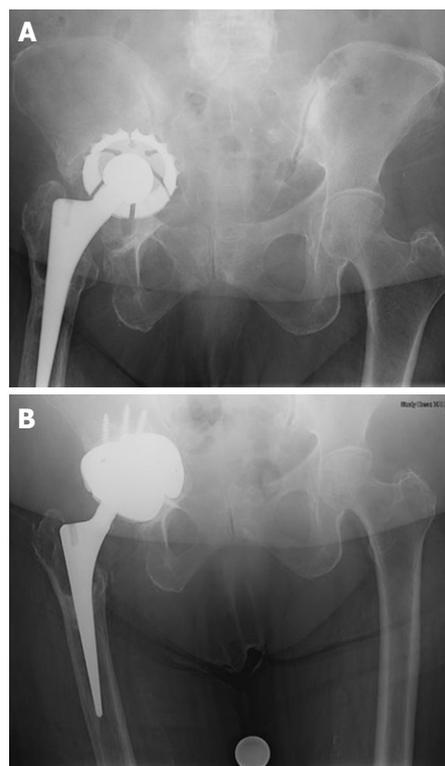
Preoperative radiograph showing failed acetabular component with large medial defect and intact rim (A) and postoperative radiograph demonstrating the revision acetabular construct using tantalum augments as “footings” to support the cup (B).
